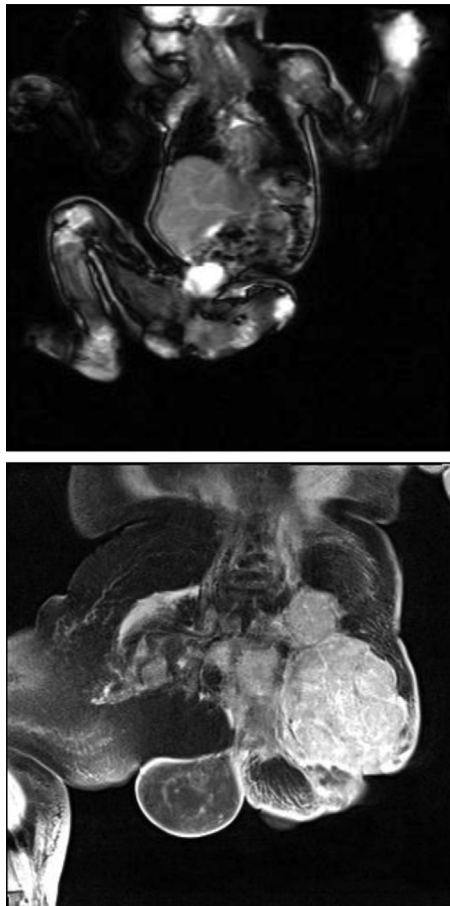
MRI of the pelvis at 1 day and 5 months showing increase in size of the lesion.
